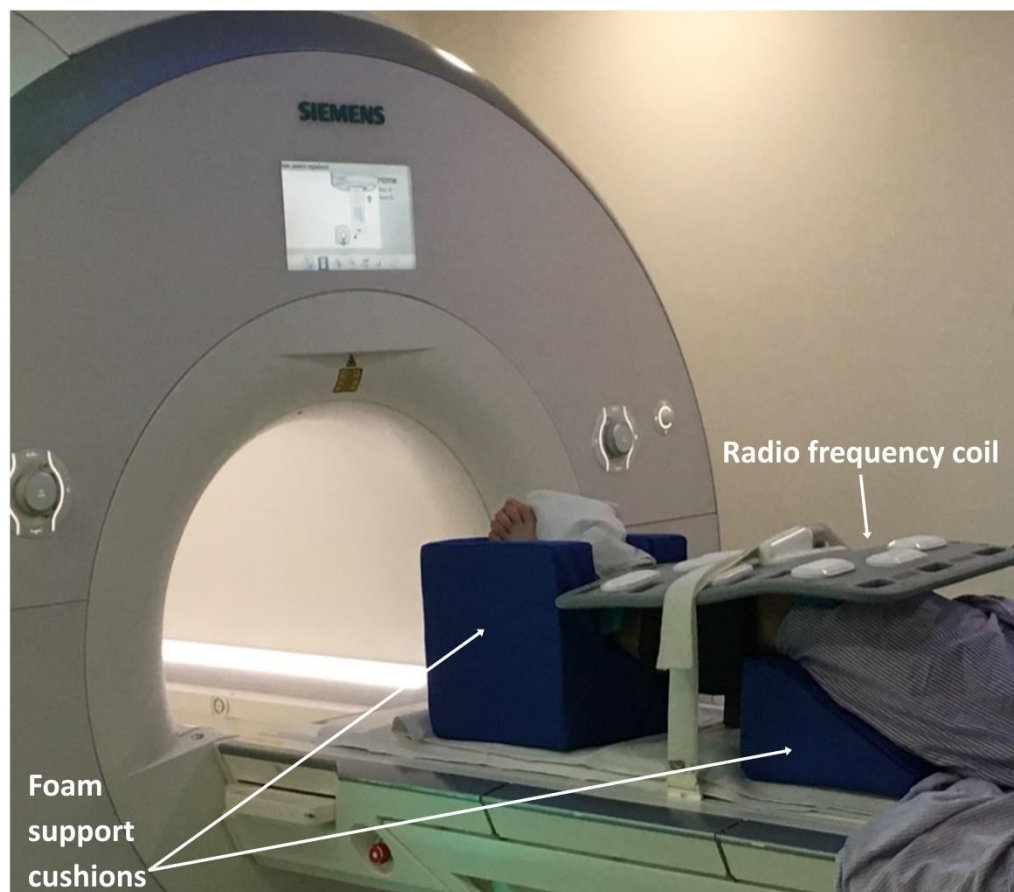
MRI testing set up
